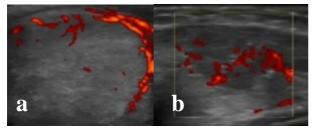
Vascular Flow of Thyroid Nodules by Color Doppler Ultrasonography. a) Peri-nodular flow (pattern 2); b) Marked intrinsic hyper-vascularity (pattern 3)
